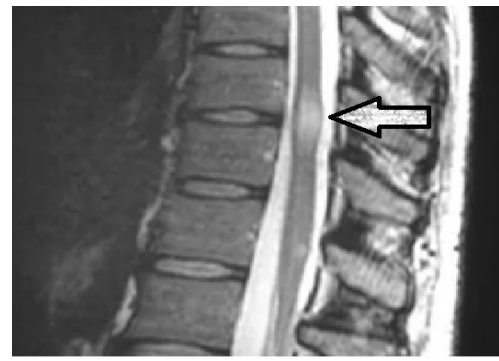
Spinal MRI (sagittal T2 flair sequence) – focal image with demyelination aspect reaching the dorsal level (T10-T11) of the medullary cord.
